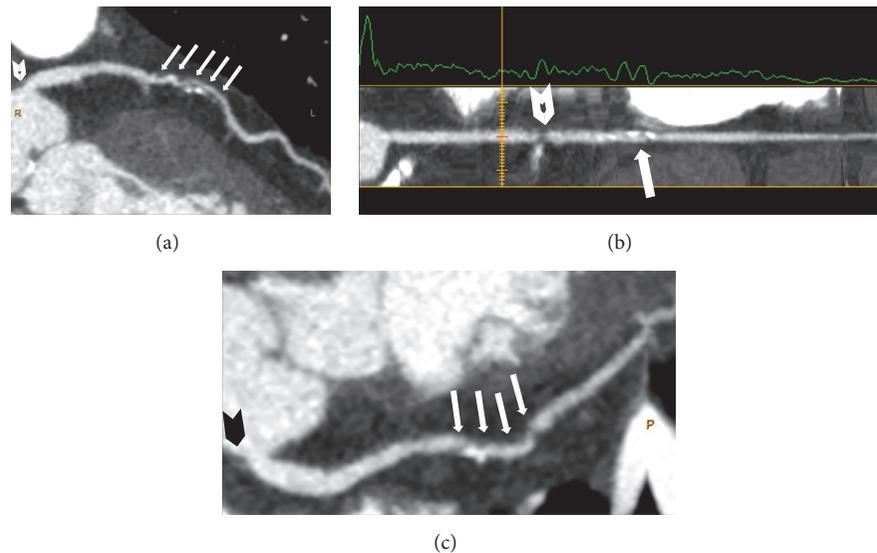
Computed tomography coronary angiography (CTCA) showing three-vessel disease. (a) Left anterior descending (LAD) artery. White arrows indicate a long, mixed, and severely obstructive plaque at proximal-middle LAD. White arrowhead shows a noncalcified, nonseverely obstructive plaque at the origin of left main artery (LM). (b) Right coronary artery (RCA). White arrow indicates a mixed and nonseverely obstructive plaque at middle RCA. White arrowhead shows a noncalcified, severely obstructive plaque at proximal RCA. (c) Left circumflex artery (LCx). White arrows indicate a long, mixed, and severely obstructive plaque at proximal-middle LCx. Black arrowhead shows a noncalcified, nonseverely obstructive plaque at the origin of LCx.
